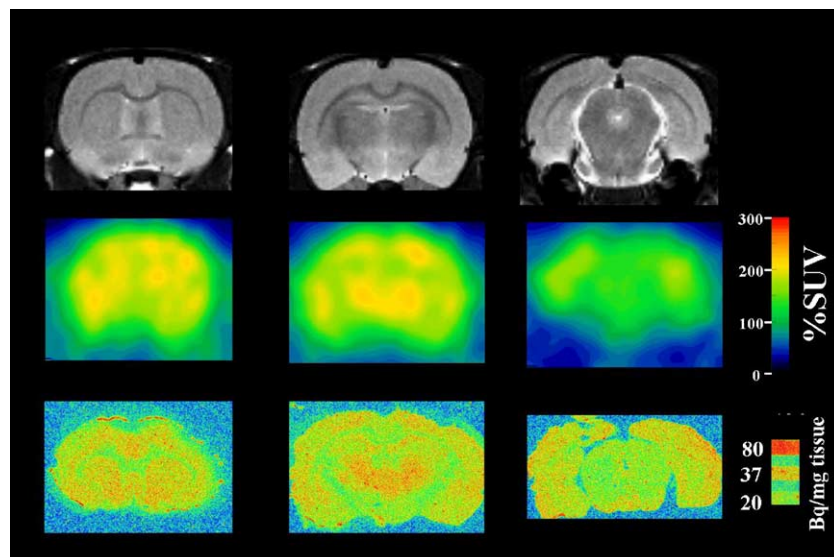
Distribution of rolipram binding in vivo. Top, middle, and bottom rows show T2-weighted MR images, integrated images from all time points of a high SA (*R*)-<sup>11</sup>C]rolipram PET experiment, and ex vivo autoradiograms using racemic [<sup>3</sup>H]rolipram, respectively. MR and PET images are in the standard space (Schweinhart et al., 2003). In the PET images, thalamus showed greatest activity followed by caudate putamen and cerebral cortices. Hypothalamus and midbrain showed low activity. The distribution of rolipram binding in the ex vivo autoradiography was similar to that of the PET experiments. Compared to cerebral cortices (31 Bq/mg tissue), thalamus showed greater (38), hypothalamus (22) and midbrain (19) showed lower activities.
